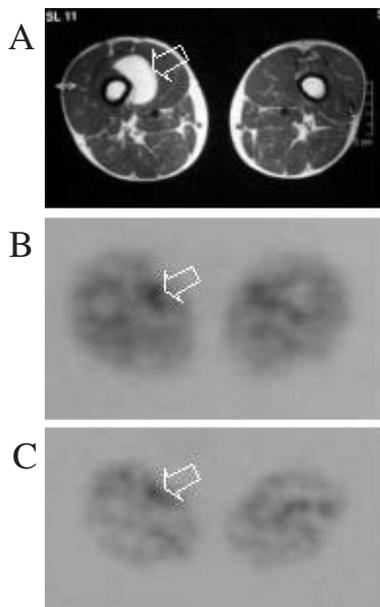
A 67-year-old male (patient number, 10) with an intramuscular lipoma of the right thigh. T1-weighted MR images (A) demonstrate homogeneous fat signals without nodular or septa structures. PET scan through approximately the same level shows mildly increased FDG (B) and FMT (C) accumulation with SUV of 0.6 and 1.2 respectively.
